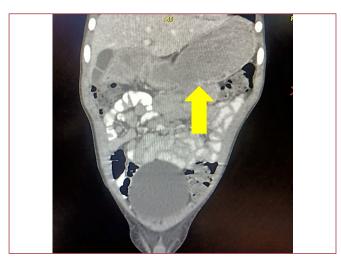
CT scan of abdomen was done and a gastro-jejunostomy was seen in place (Yellow arrow)
